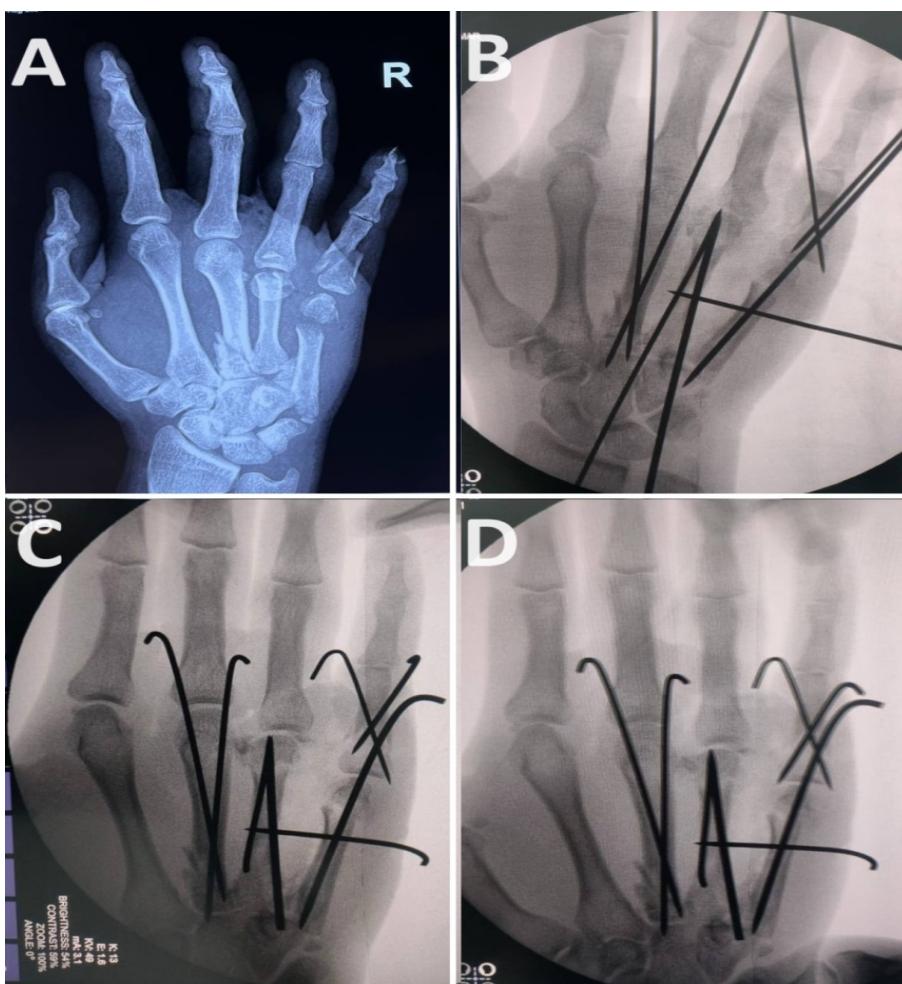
Importance of taking c-arm images after bending the k-wires. (A) Pre-operative radiograph showing multiple metacarpal and phalanx fractures. (B) Intra-operative c-arm image showing satisfactory k-wire placement, before bending of k-wires (C) C-arm image after bending of k-wires. One of the k-wires used to fix the 5th proximal phalanx fracture appears to have retracted/been pulled out partially when bending the k-wire. (D) Taking the c-arm image after bending of k-wires allows you to reposition the k-wires correctly even after bending the k-wire like in this case.
